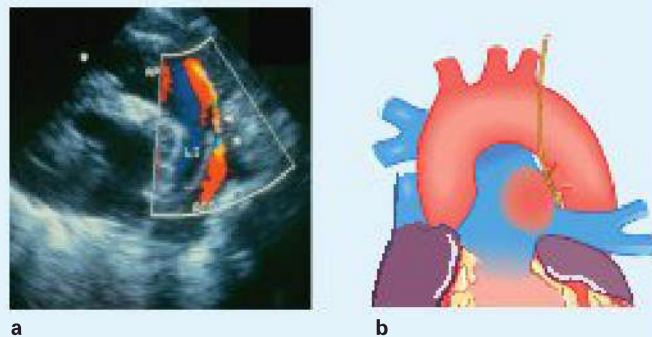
a A colour Doppler examination. [O548]
